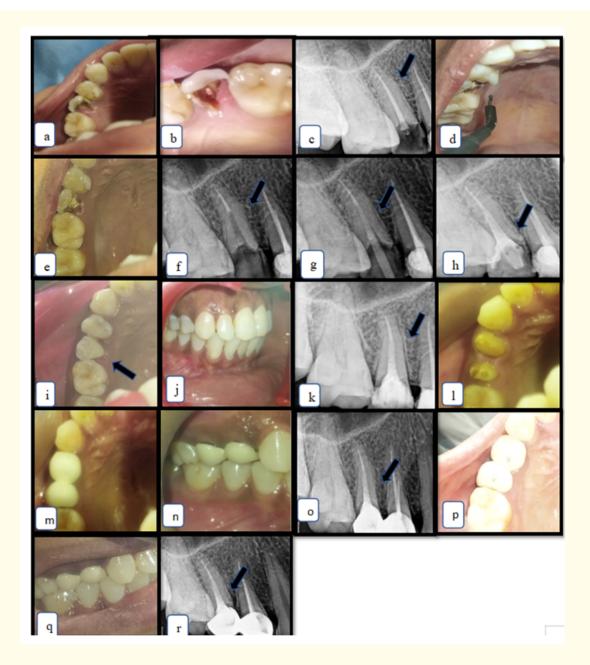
(a) and (b) pre-operative image (c) pre-op radiograph (d) image showing crown lengthening with electrosurgery irt 15 (e) immediately after crown lengthening (f) post space preparation irt 15 (g)post placement (h)post cementation irt 15 (i) radiograph after core build up irt 15 (j) and (k) image after core build up irt 15 (l) crown preparation irt 14,15 (m) and (n) image showing crown placement irt 14,15 (o) radiograph after crown cementation (p) and (q) intraoral image of 3 month follow up (r) radiograph after 3 month follow up.
